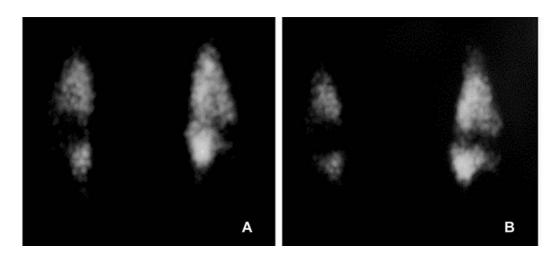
Scintigraphs of stifle uptake 8 weeks after left cranial cruciate ligament transection. LEGP collimator scintigraphs were obtained 2 h after ^{99m}Tc -DPD (A) and 3 h after ^{99m}Tc -MPD (B) injection. Images A and B show concentrated abnormal increased activity in the left stifle joint.
